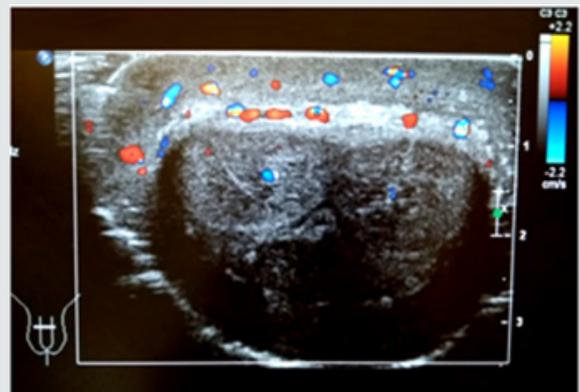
Penile ultrasound at arrival. Important oedema of the soft tissue sparing muscular tissues. Good permeability of vascular structures reported by the radiologist.
